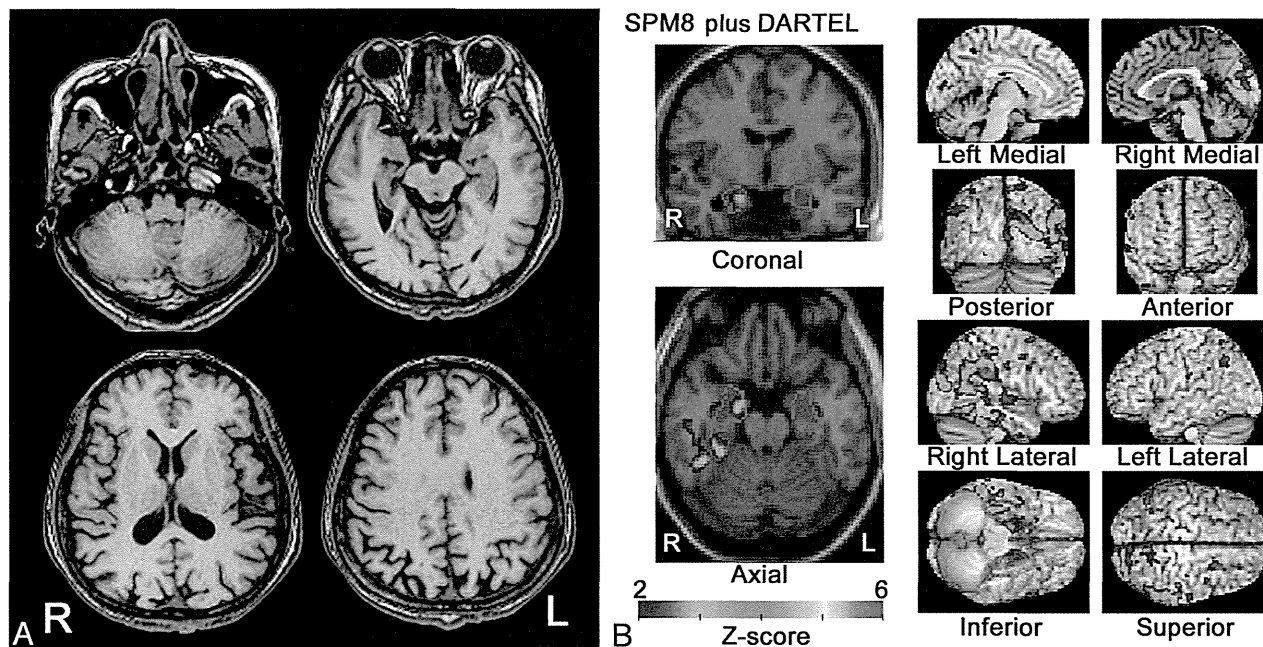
Cross-sectional VBM study by using SPM8 plus DARTEL. A, MR image of a 52-year-old woman with an MMSE score of 27. One year later the MMSE score declined to 19. B, SPM8 plus DARTEL analysis with global normalization reveals a significant decrease of gray matter volume in the right entorhinal area. Colored areas with z scores of >2 are overlaid as significantly atrophied regions on tomographic sections and cortical surface of the standardized MRI template. A target VOI in the medial temporal structures is demarcated with purple lines. The right temporoparietal cortex also shows extensive significant atrophy.
